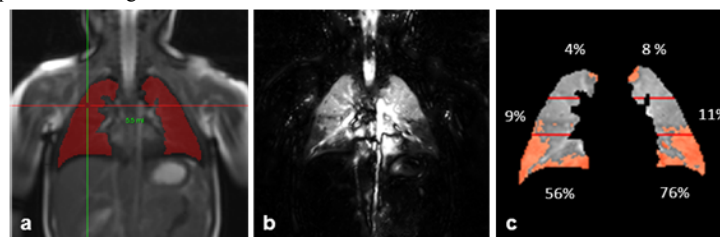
Semi-automatic lung segmentation of SSFP data in a 4 years old male CF patient (a), perfusion-weighted FD MRI (b), quantification of regional perfusion defects (c). Percentage of the impaired tissue has been estimated for every lung area.
